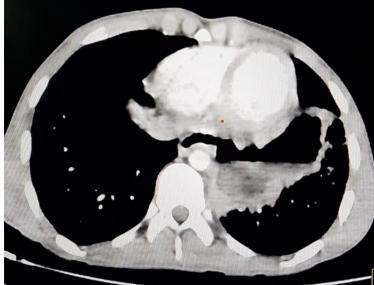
chest CT images showing pleural collection with air-fluid level (signs for empyema).
